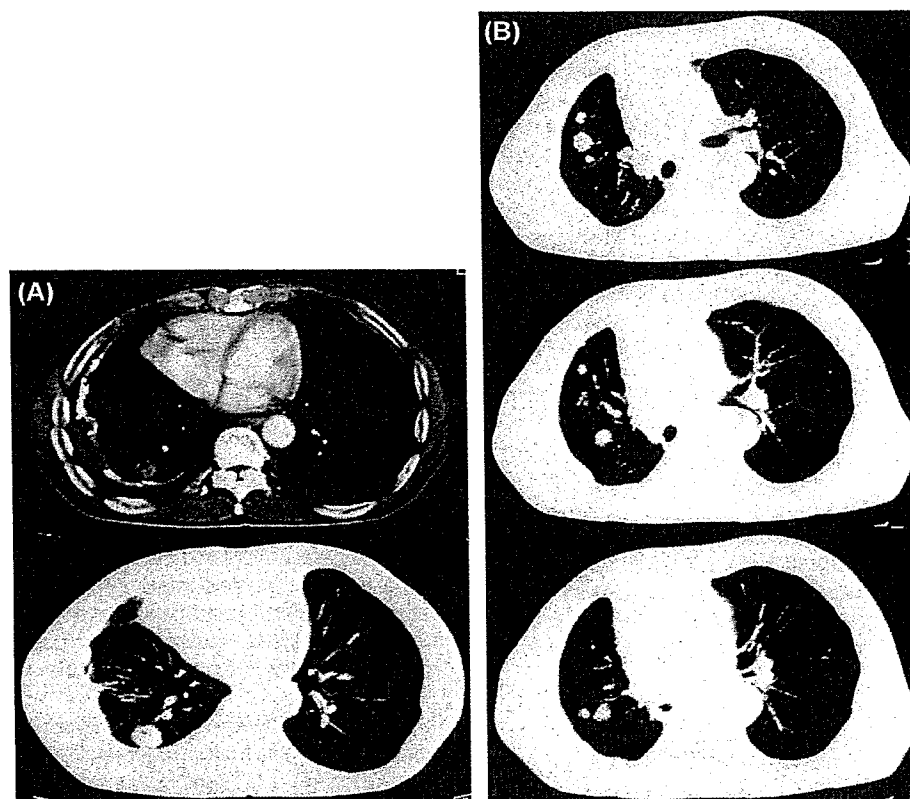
An axial CT image of patient 1 at the first operation shows a small nodule with a cavity in the right lower lobe (A). Axial CT images of patient 1 at the second operation show multiple small nodules in different ipsilateral lobes but no nodules in the contralateral lung (B).
